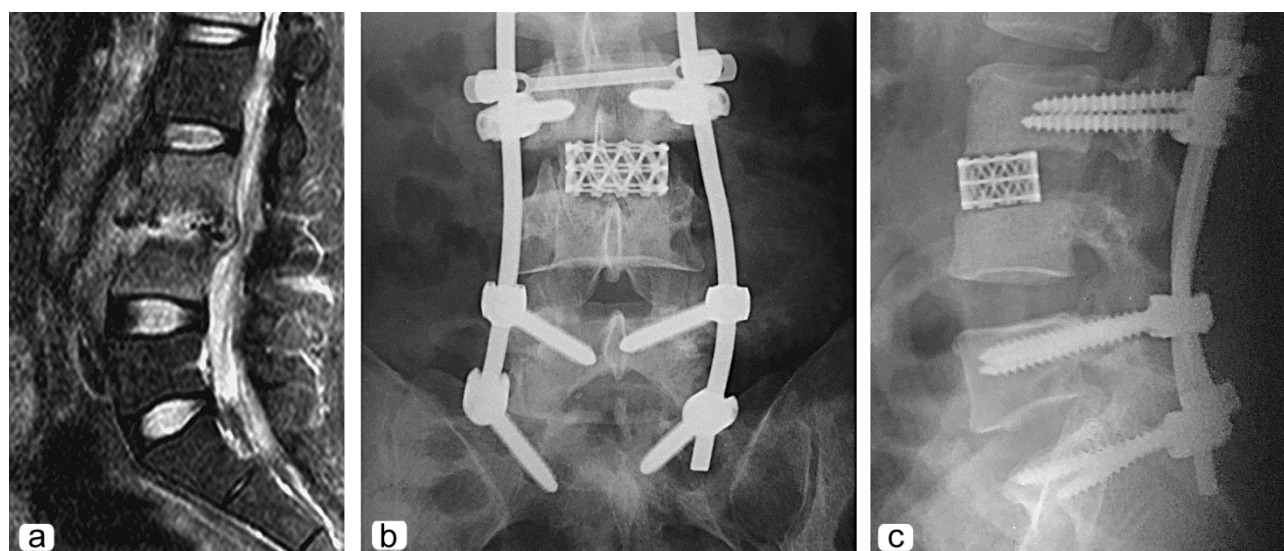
A 28-year-old patient Kh. with tuberculous spondylitis of L₃ - L₄ vertebrae: (a) preoperative CT scan of lumbar spine showing destruction of L₃ and L₄ vertebral bodies with lower height of L₄ vertebra, caseously compressed spinal cord, paravertebral abscess; (b, c) AP and lateral views of spondylograms 2 weeks after combined spondylodesis
